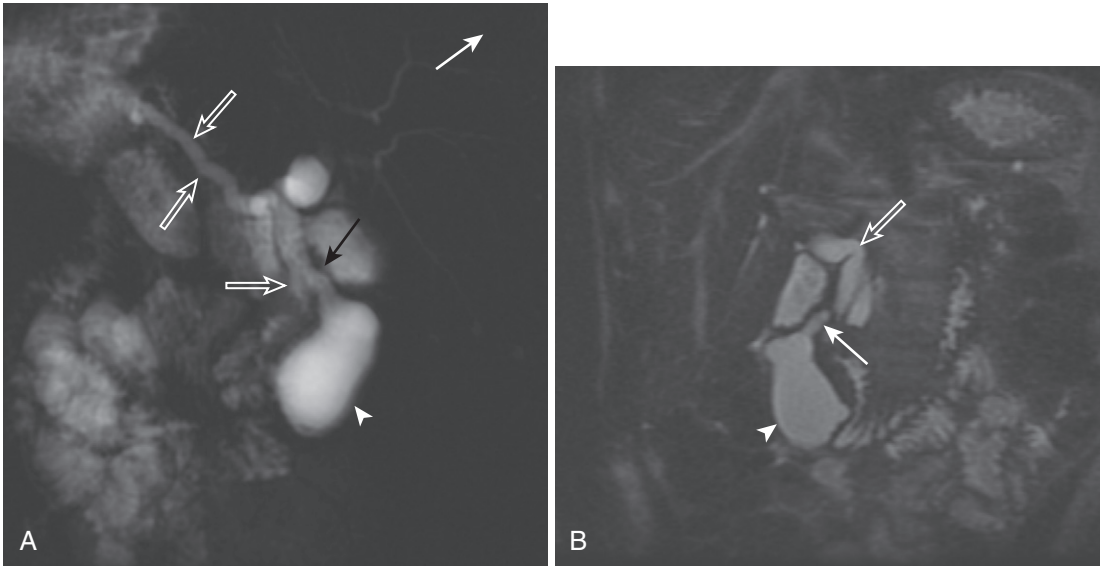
Type II choledochal cyst. A narrow channel (*arrow*) connecting the saccular type II choledochal cyst (*arrowhead*) with the common bile duct (*open arrows*) is better depicted on the thick-slab 2D MRCP image (A) compared with the coronal T2-weighted SSFSE image (B) due to the relatively thinner slices and lack of orientation along the plane of the connecting channel.
